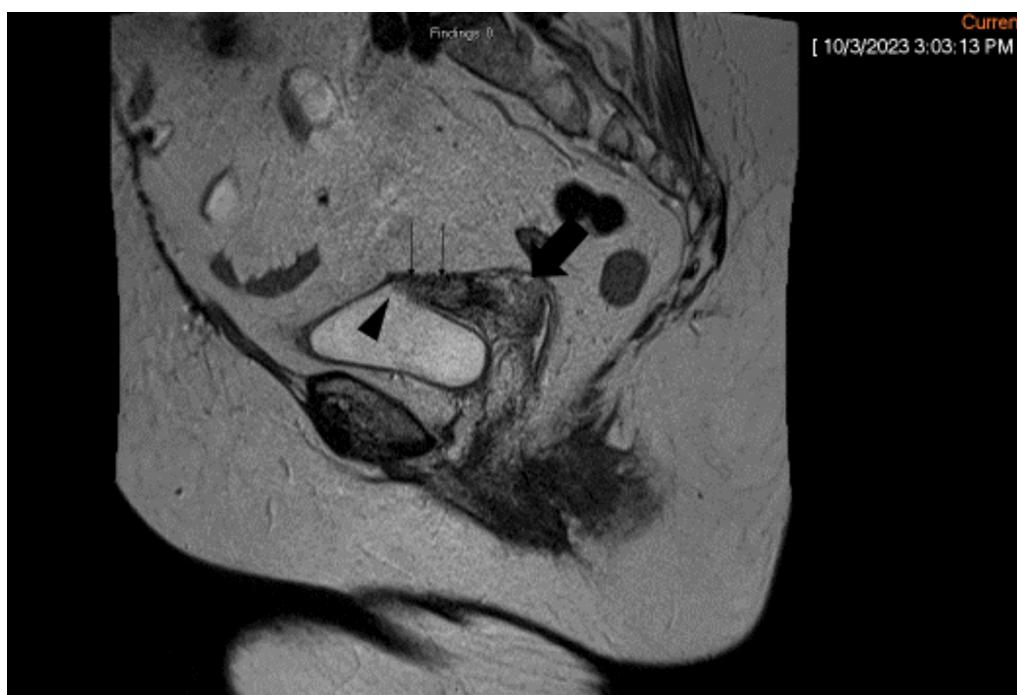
MRI left paramedian sagittal view of the cervix (thick arrow) with tumor (thin arrows) frankly invading the bladder (arrow head).
